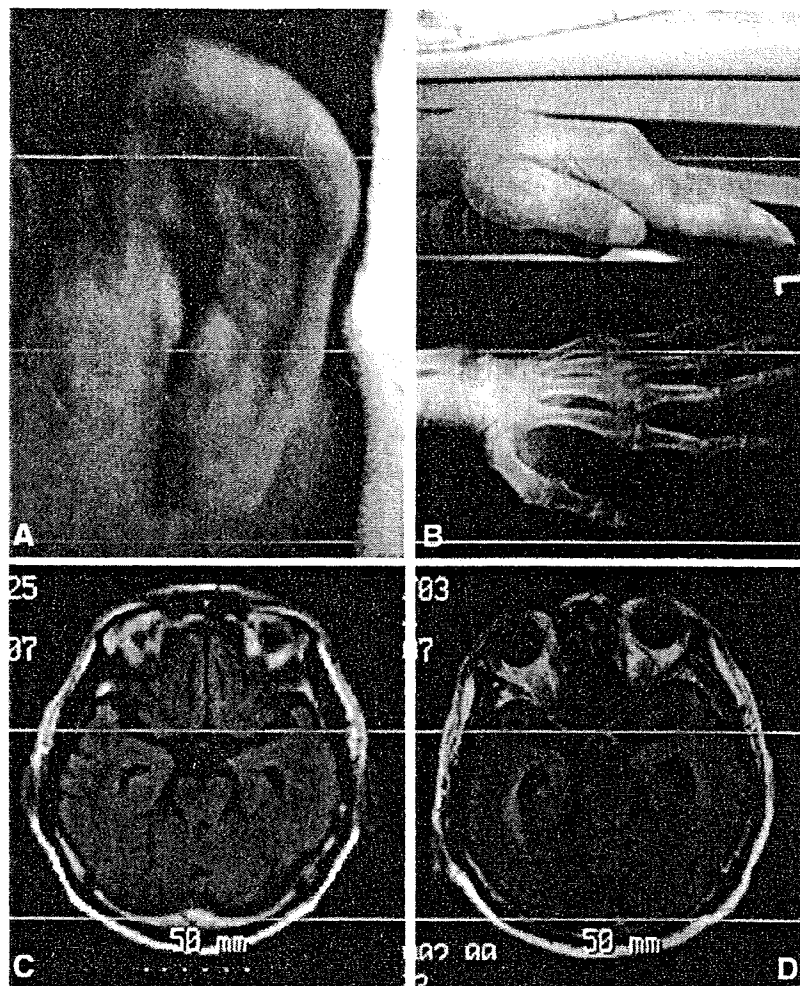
The patient's clinical characteristics. A: Ear swelling, B: finger deformity, C: fluid-attenuated inversion recovery MR image of the brain at first admission showing a slightly high signal intensity lesion in the medial temporal lobe, and D: brain MR image 14 months later showing marked atrophy of the medial temporal lobe bilaterally.
